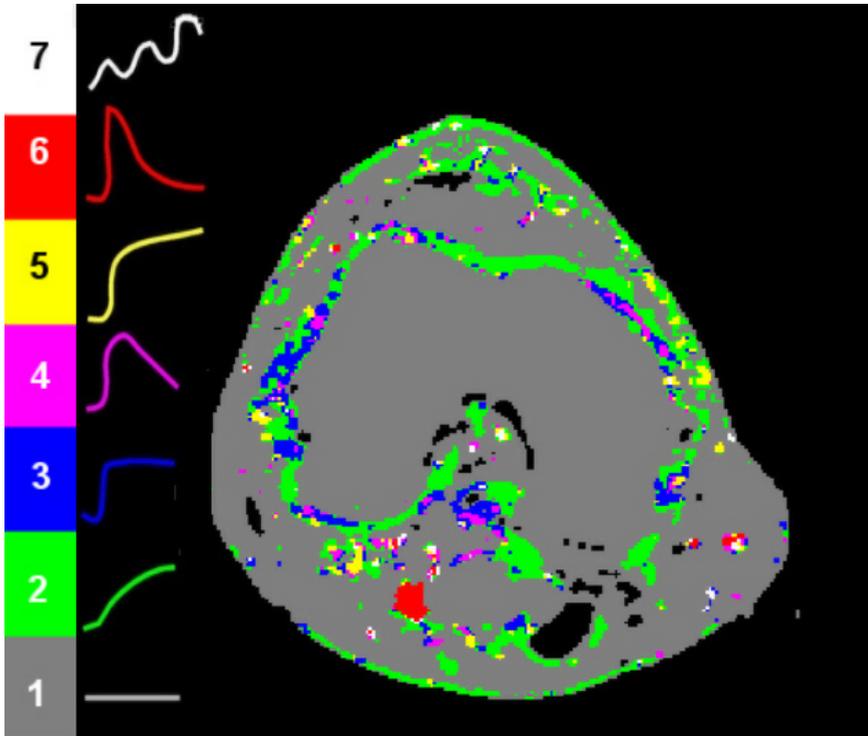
A cross sectional image from a DCE-MRI scan of a knee joint, post-processed using TIC-shape analysis. The distribution of the various TIC-shapes (legend left side) across the joint is easily visualized.
